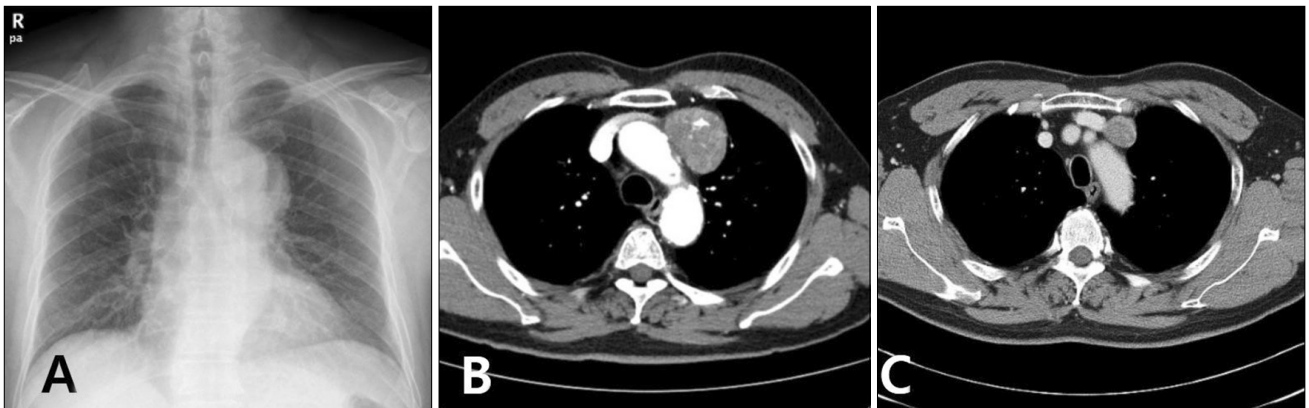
Chest radiographs. (A) A chest X-ray showing a mass-like opacity at the anteroposterior window and (B) a chest CT axial view showing a 5.6-cm irregular mass with calcification encasing the left brachiocephalic vein, without any attachment to the bony thorax at the time of admission. (C) A CT axial view, taken 5 years previously, showing a 2.6-cm mass with no involvement of nearby vessels. CT, computed tomography.
